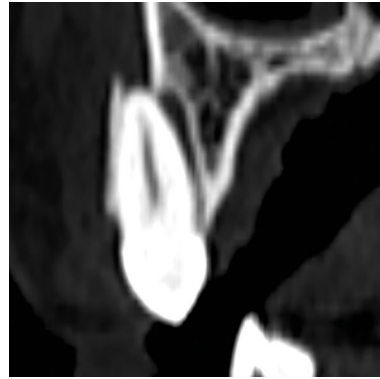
CBCT identifying lateral luxation of the 13 subsequent to assault. This injury was not identified at the initial clinical examination stage
